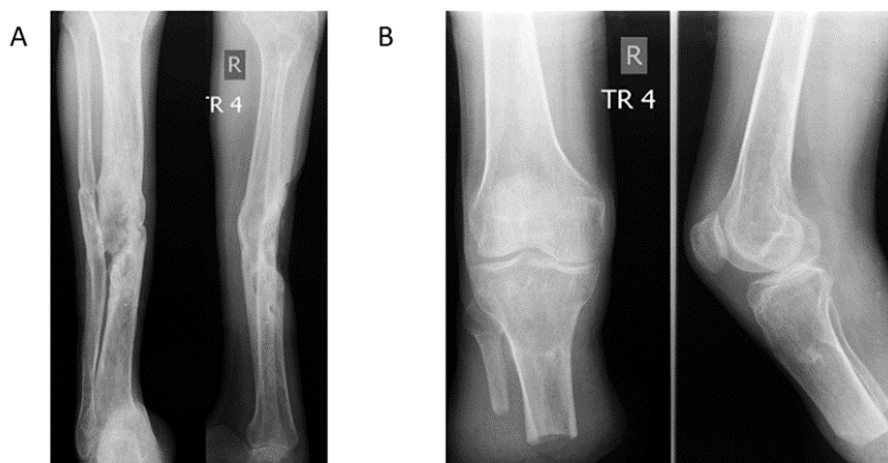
(A) Radiographs of the right lower leg (anteroposterior and lateral views) at admission, demonstrating radiographic signs consistent with chronic osteomyelitis of the tibia. (B) Follow-up radiographs of the right lower leg (anteroposterior and lateral views) after amputation at the level of the proximal third. The bone transection surface appears regular; the stump is well formed, with no radiographic evidence of residual bone destruction
